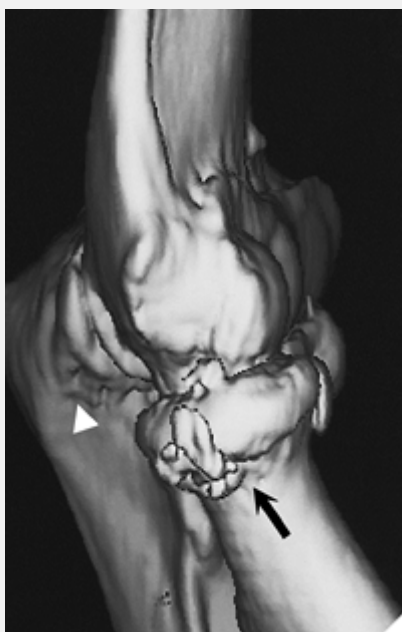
CT three-dimensional imaging. Three-dimensional CT reformation of the elbow shows a fracture of the neck of the radius (*arrow*) and fracture of the olecranon process (*arrowhead*).
